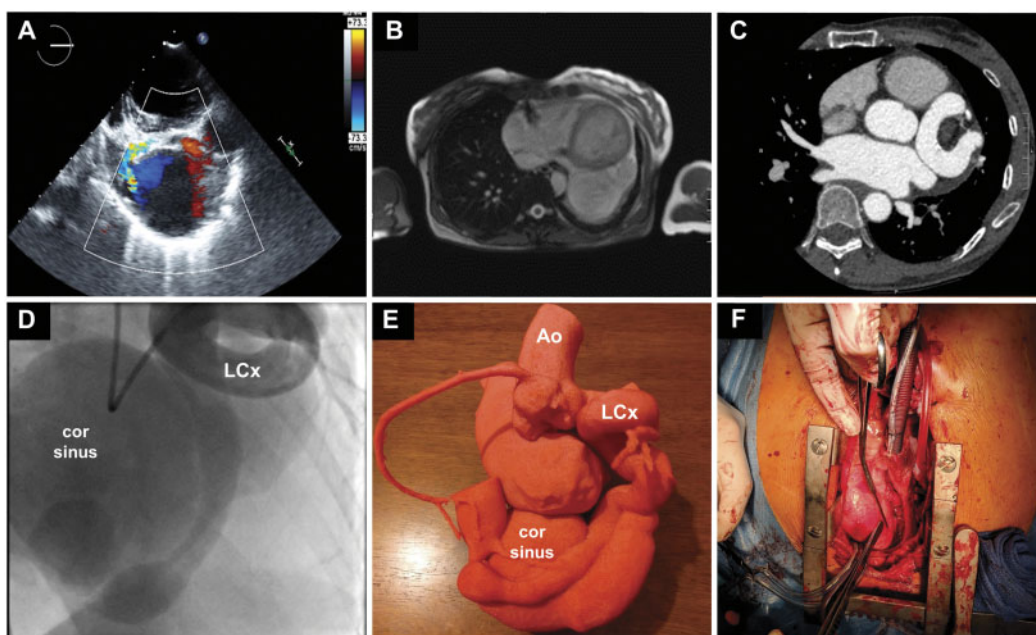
(A) TOE demonstrating the dilated coronary sinus with colour-flow Doppler. (B) Cardiac magnetic resonance imaging axial view highlighting the coronary sinus size. (C) Cardiac computed tomography axial view demonstrating the enlarged and tortuous left circumflex artery. (D) Invasive coronary angiography of the left coronary artery system demonstrating contrast filling of the coronary sinus. (E) Annotated three-dimensional printed model showing the size, course, and anastomosis of the fistulous left circumflex artery. (F) Intraoperative photo of the surgeons view after sternotomy.
